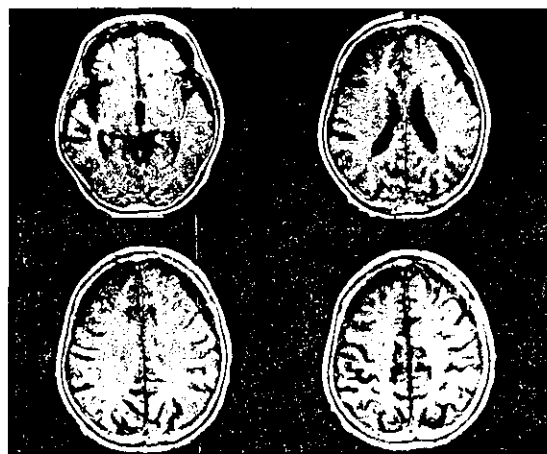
MRI of the head, showing round enhancing lesions on cortex of bilateral anterior and temporal area
